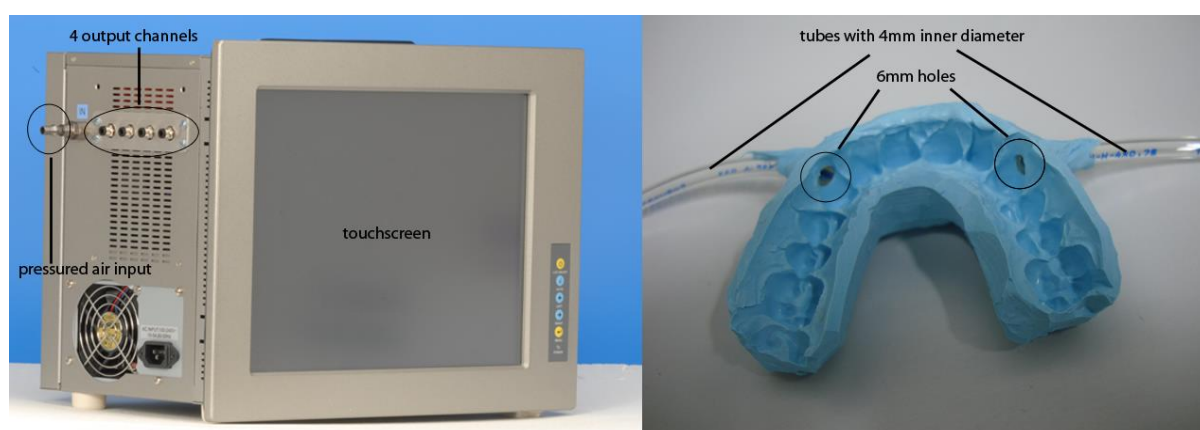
Left: MRI compatible multi-injector gas jet delivery system with touch screen. Right: Individual dental polysiloxane impression
